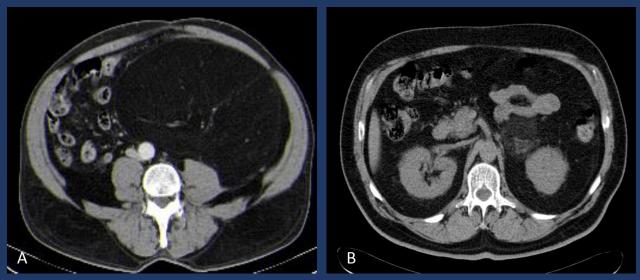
Well-differentiated liposarcoma – Axial contrast-enhanced CT reconstrutions demonstrates a wellcircumscribed mass, predominantly fatty (>75%), with enhancing septations > 3mm in thickness in two differente pacientes (A and B).
